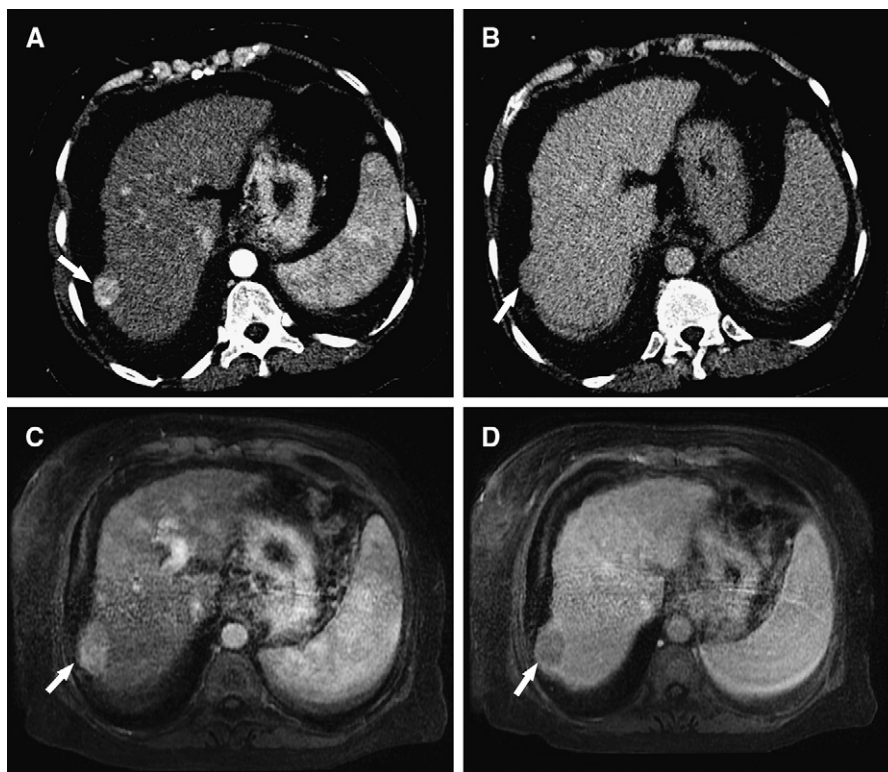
(A) A 60-year-old woman with hepatitis C and liver cirrhosis. Contrast-enhanced transaxial computed tomography with a liver mass (arrows), demonstrating arterial enhancement and subtle washout to hypoaattenuating to the liver parenchyma on the portal venous phase (B). (C) Gadolinium-enhanced liver acceleration volume acquisition magnetic resonance imaging sequences with corresponding arterial enhancement and washout on the portal venous phase of the liver mass (arrows) (D).
